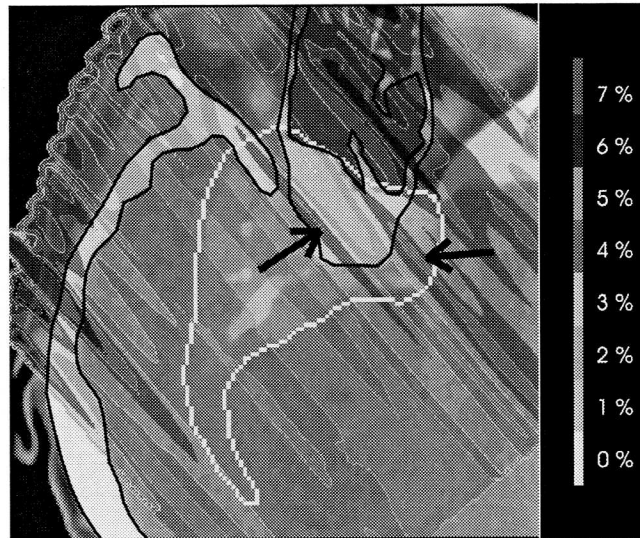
Estimated relative range dilution for the meningioma case. The range dilution values are overlaid in grey scale on the CT image. The relevant bony structures are enhanced for a better display. It can be seen that highest range dilution (arrows) is found in the same areas as the largest dose differences in Fig. 36.
